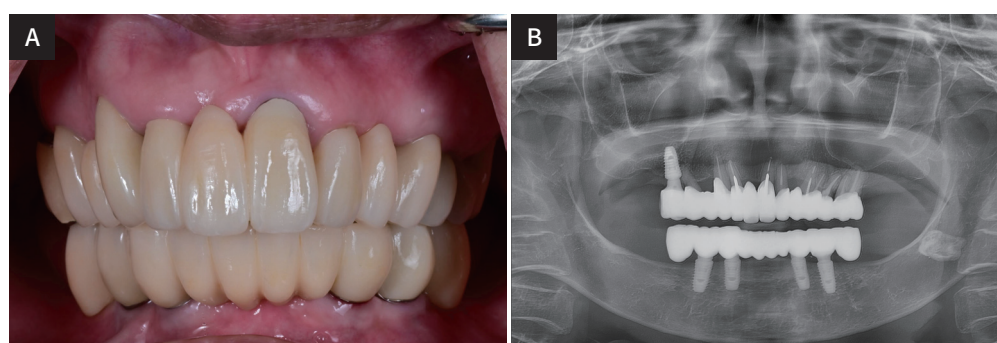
Definitive prostheses. (A) Intraoral photograph: frontal view, (B) Panoramic radiograph.
